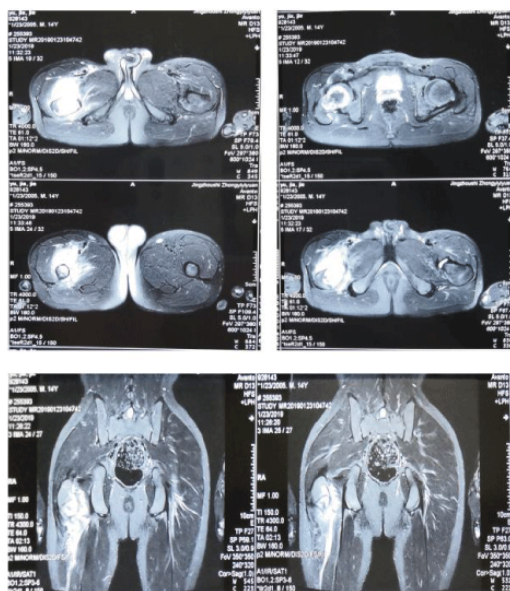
The MRI imaging of hip joint prompt there was a bone tumor-like lesion or tumor. What's more, eosinophilic granuloma have to be excluded.
